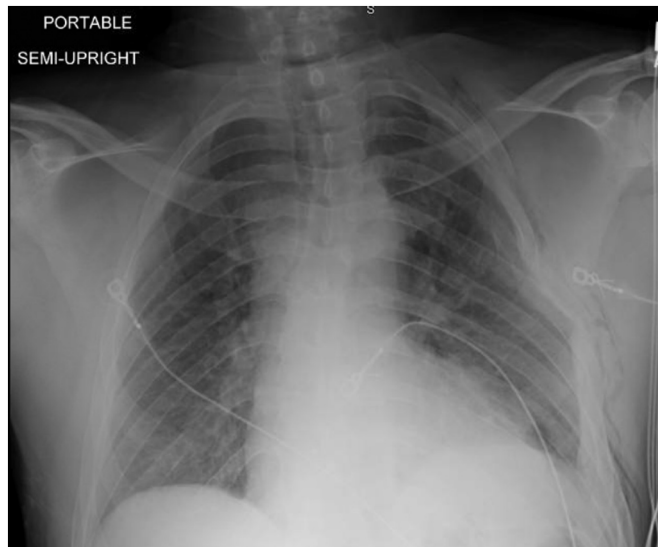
Initial chest radiograph.
